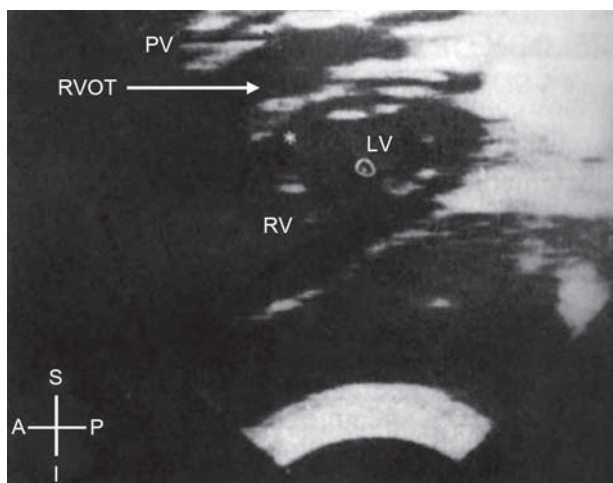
Echocardiography (two-dimensional) in tetralogy of Fallot. Abbreviation: RVOT, right ventricular outflow tract.
